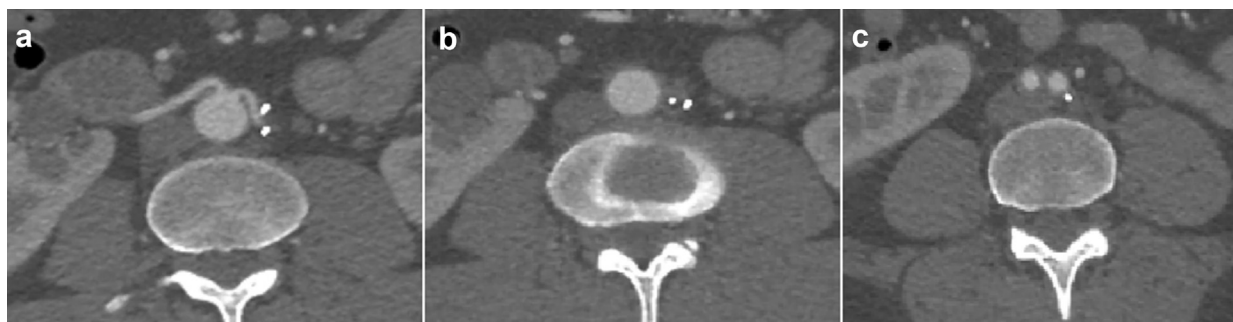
Postoperative computed tomography scan beginning proximally at (a) accessory renal artery (ARA) origin and going distally into (b) aorta as well as (c) aortic bifurcations. Images were captured at the same level as preoperative imaging shown in Fig 1.
